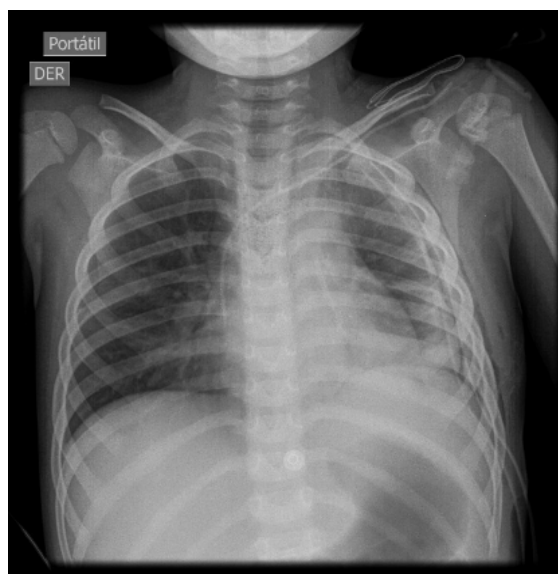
Pre-discharge posteroanterior (AP) (Figure 5A) and lateral chest radiographs (Figure 5B) showing an image of consolidation in the left hemithorax, with dense alveolar infiltrate, effacement of the costodiaphragmatic and left angle, and elevation of the ipsilateral hemidiaphragm.
